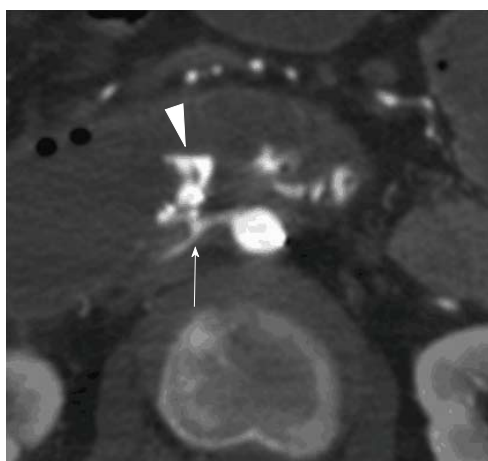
Contrast-enhanced computed tomography shows extravasation into the duodenal lumen (arrowhead) from the right renal artery (arrow).
